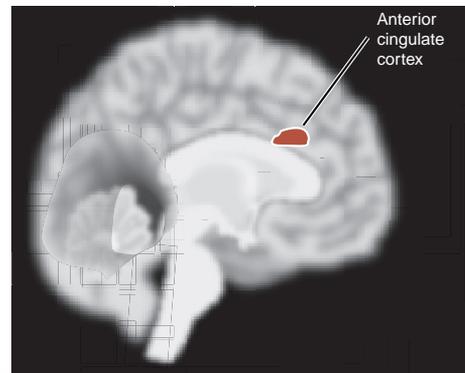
• A. Neuropsychological testing improved after 40 sessions of neurofeedback. B. The anterior cingulate cortex showed greater activity after the neurofeedback treatment. (Adapted from Levesque J, Beauregard M, Mensour B. Effect of neurofeedback training on the neural substrates of selective attention in children with attention-deficit/hyperactivity disorder: a functional magnetic resonance imaging study. *Neurosci Lett.* 2006;394(3):216-221.)
